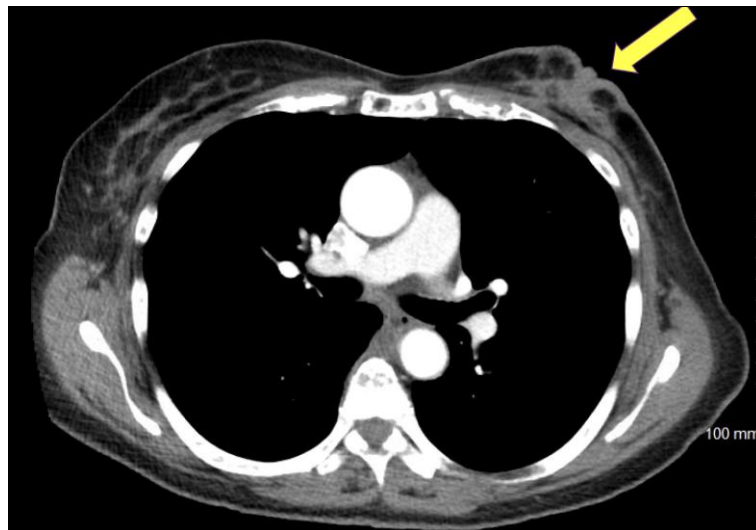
CT chest showing breast asymmetry. The left breast demonstrates concern for mass, skin thickening, and nipple retraction (arrow).
